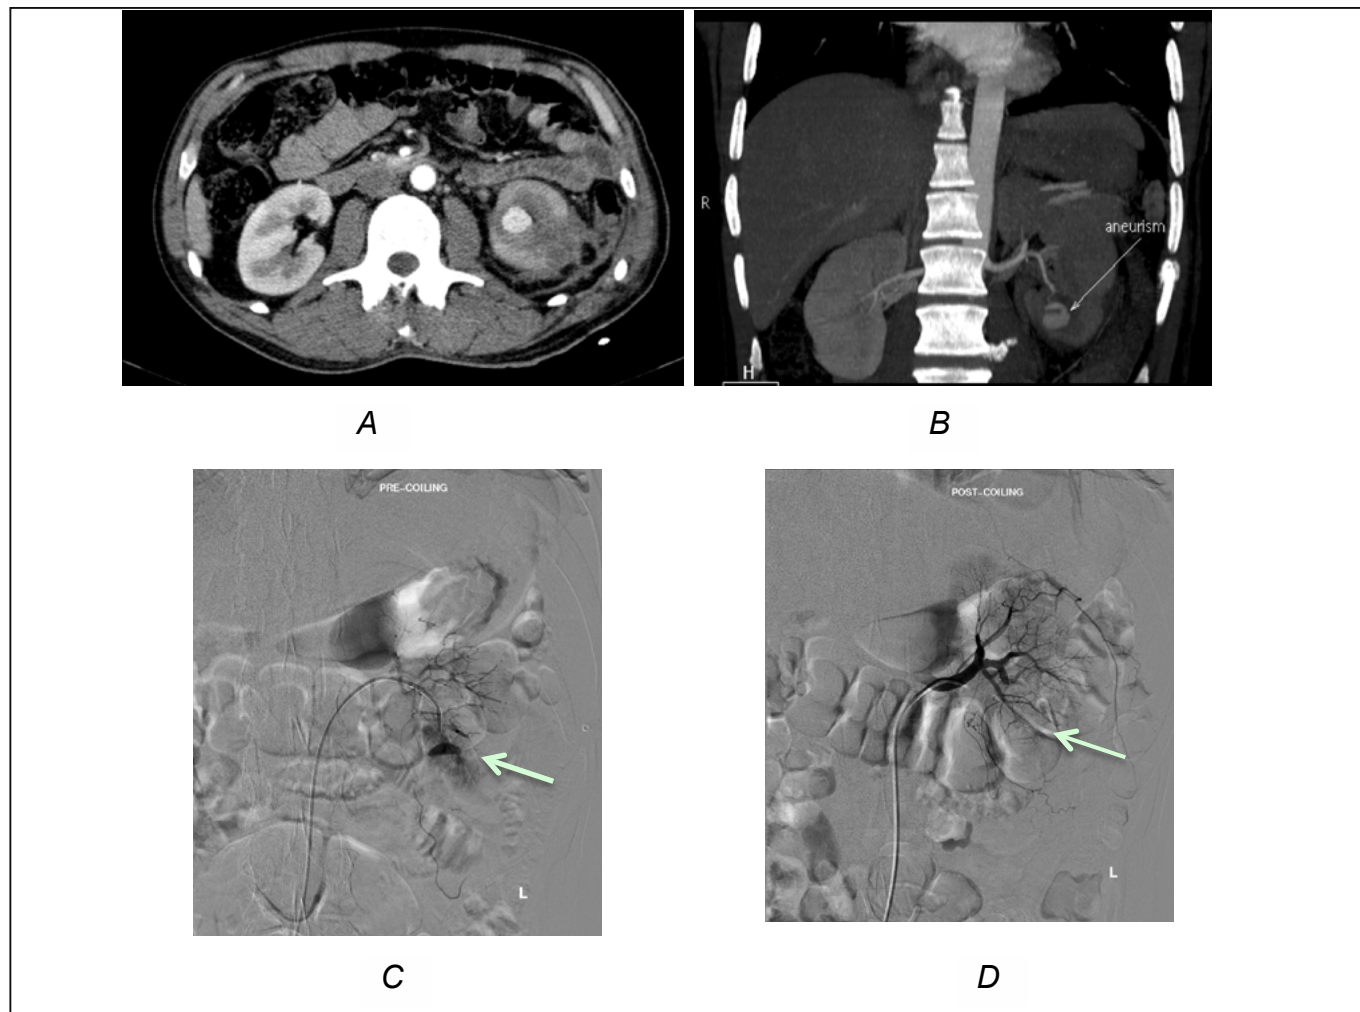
The lower segment of the anterior branch of the left renal artery was injured with a stab wound. A pseudo-aneurysm can be seen on the (A) axial- and (B) coronal views of the arterial phase of the CT IVP. (C-D) Sequential digital subtraction angiograms are seen. Pre-embolisation images delineate exact position. Successful employments of coils to occlude the bleeding vessel are shown, with resolution of the aneurysm and good collateral blood flow.
